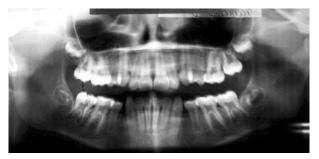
Progress panoramic radiograph.
